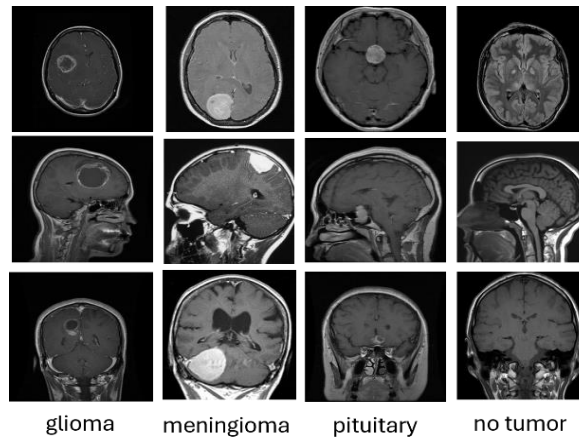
Examples of glioma, meningioma, pituitary, and no tumor in MRI images
